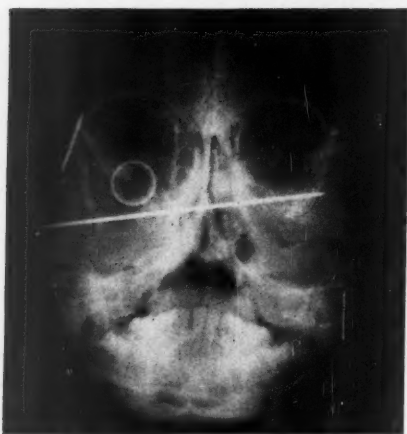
X-ray of patient shown in figure 4 (*bottom right*). Transverse and vertical Kirschner wires and twisted no. 26 individual wires fasten the few remaining malar and lateral orbital fragments to the skull.
